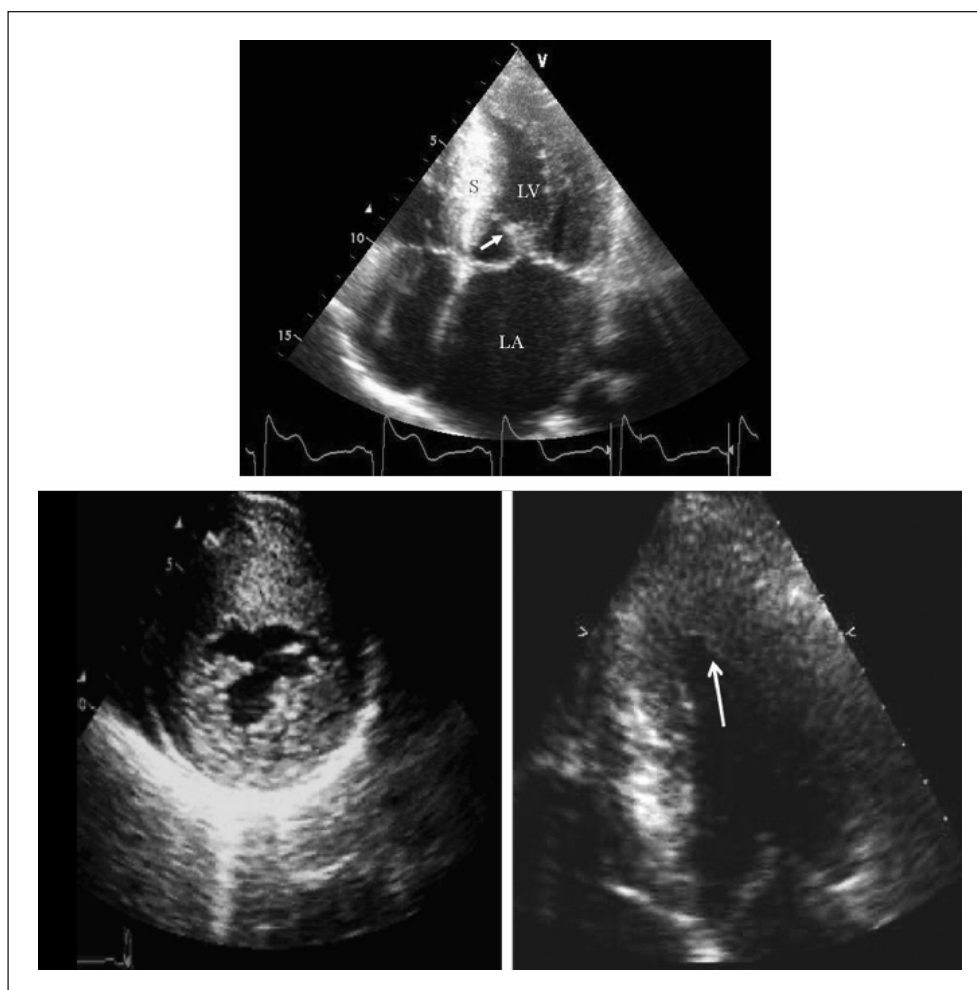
Hypertrophic cardiomyopathy is primarily diagnosed by echocardiography
